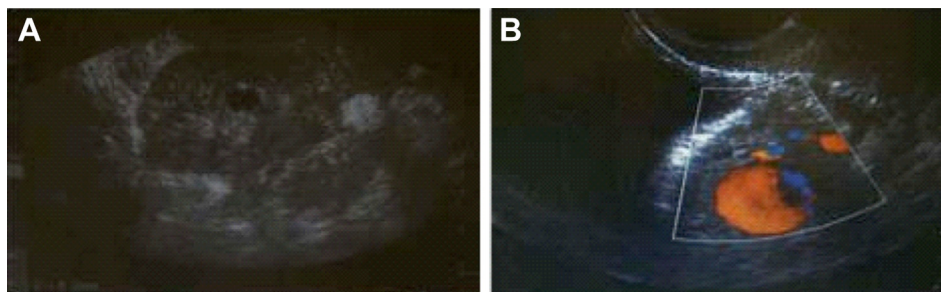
(A) Grayscale ultrasound imaging showing a 1.5-cm anechoic lesion in the uterine cavity. (B) Color Doppler imaging showing swirling blood flow with a to-and-fro pattern in the intrauterine cystic lesion.
